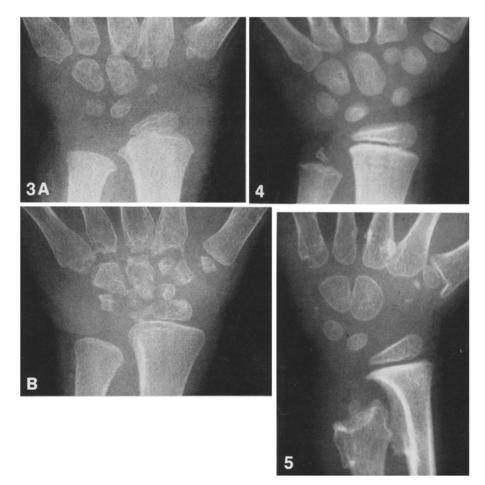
Wrist X-ray of a child with juvenile rheumatoid arthritis at age 2.5 years (A) and 3.5 years (B). Increase of ulnar shortening with progressive disease. Measurements A and B were 3.5 mm and 4.5 mm at age 2.5 years which is at about the 95th percentile. They increased to 6 mm and 5 mm at age 3.5 which is well above the 95th percentile. Note the tendency towards ulnar subluxation of the carpals
